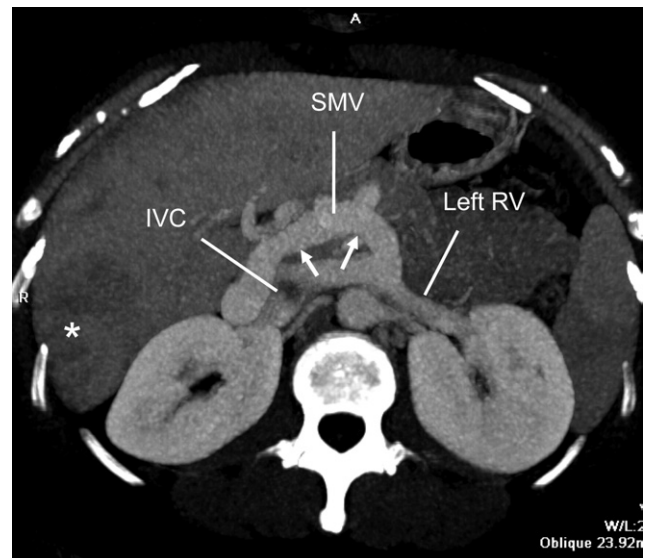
A 38-year-old woman with history of multiple aortic surgeries and cardiac arrhythmia underwent follow-up CTA study for splenic artery aneurysm and chronic occlusion of the splenic and portal veins. Axial MIP image of portal venous phase shows large venous shunts (arrows) between the SMV and the inferior vena cava (IVC) and SMV and the left renal vein (RV). Note the inhomogenous and delayed parenchymal enhancement of the liver (*) on the arteriovenous phase.
